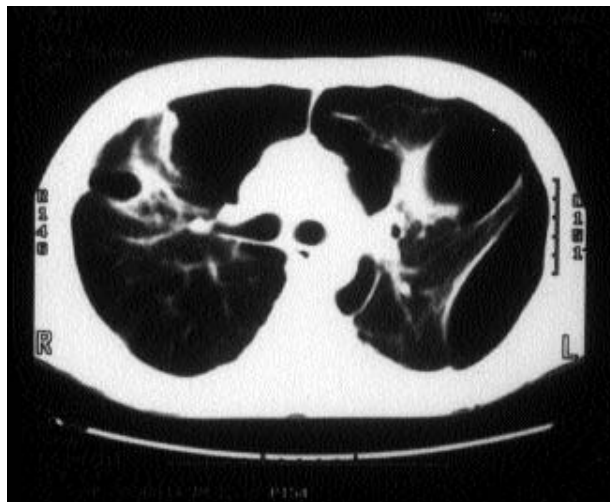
Computed tomography of the same patient in figure 1, 6 days after trauma. Severe barotrauma with pneumomediastinum, pneumothoraces and several pulmonary air cysts can be seen.
